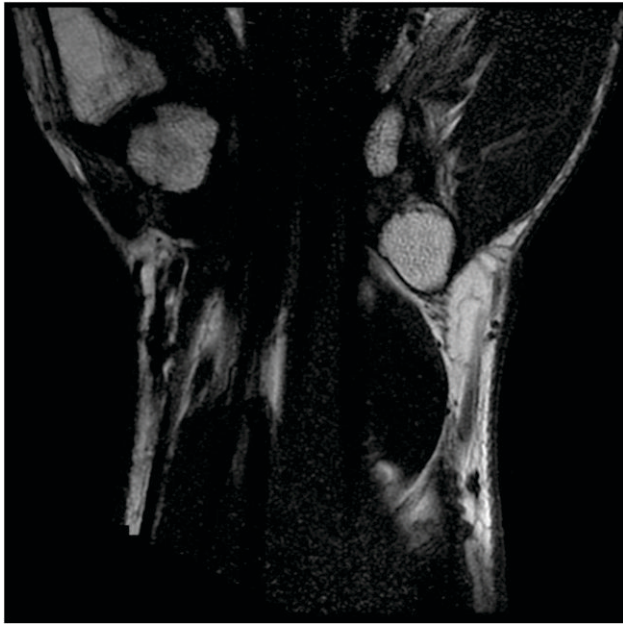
T1-weighted magnetic resonance image of patient's ganglion within Guyon's canal*
